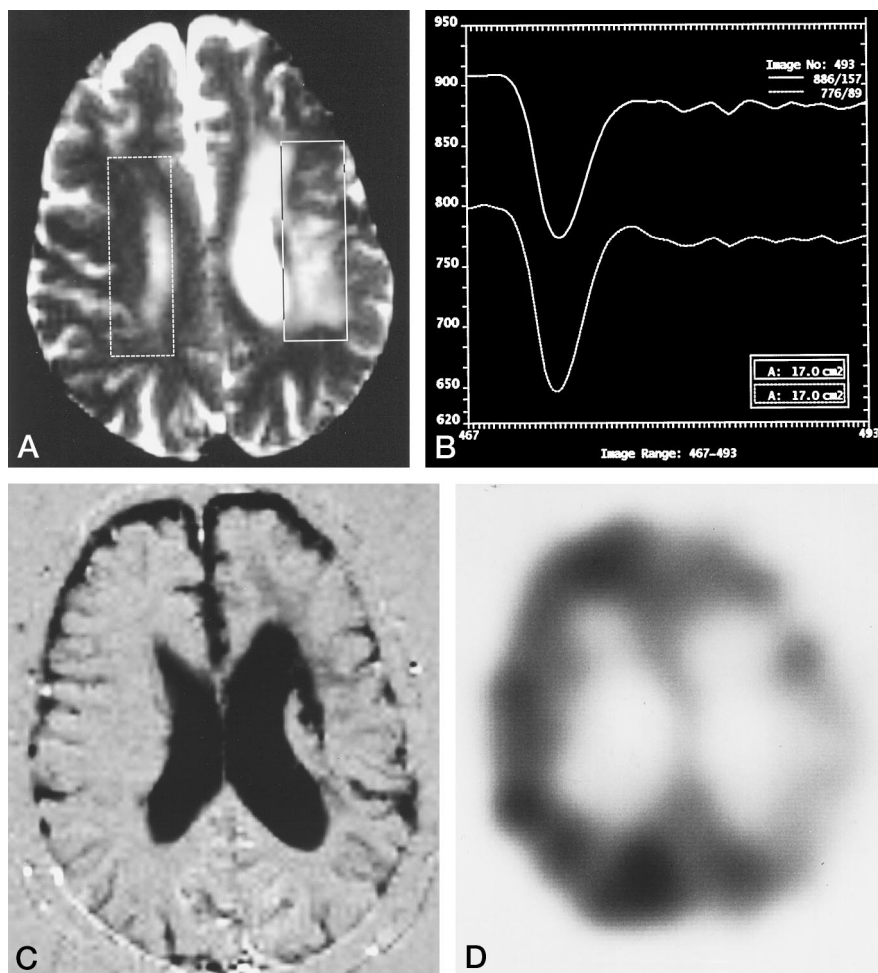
Case 17: 59-year-old woman with moyamoya disease equally affecting both sides. MR images showed a partially hemorrhagic old infarction in the left frontal lobe.
